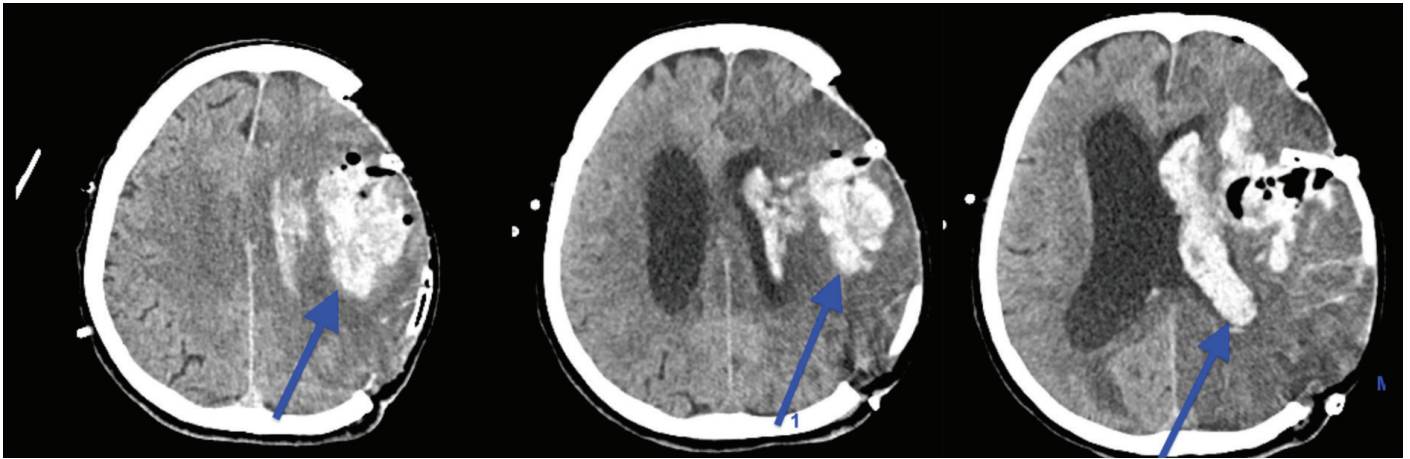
Arrows show hemorrhage areas on CT images in different sections
